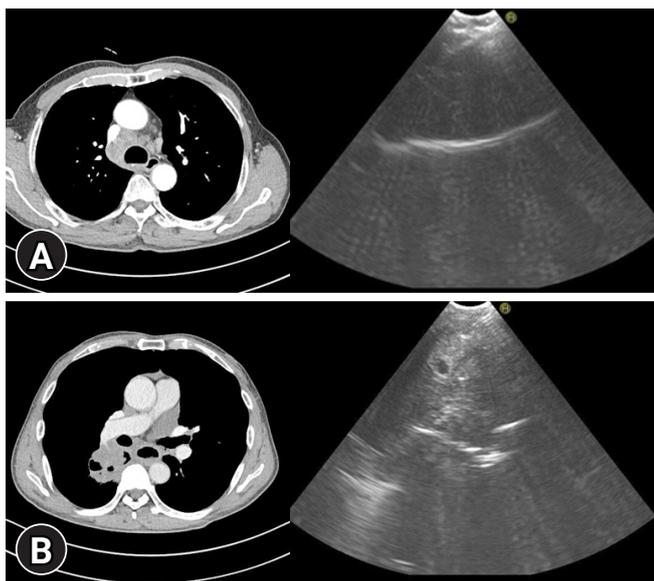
Axial images of chest computed tomography and convex probe-endobronchial ultrasound-transbronchial needle aspirator for the right paratracheal lymph node (A) and the central lung mass (B).
